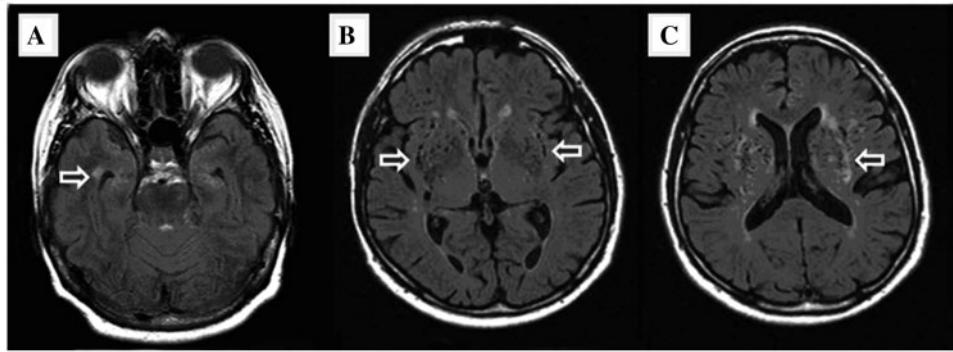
MRI findings suggestive of CADASIL in carriers of rare non-synonymous single nucleotide polymorphisms. Axial fluid-attenuated inversion recovery MRI images. (A) Subject 1350 with a V764A amino acid exchange showing a hyperintense rounded area of signal hyperintensity in the temporal lobe directly adjacent to the temporal horn of the lateral ventricle (*arrow*). Although signal changes at this location are not typically seen with age-related white matter changes, the abnormality can also not be considered specific for CADASIL, because CADASIL lesions usually extend to the most anterior parts of the temporo-polar white matter. (B) Subcortical lacunar lesions which have been reported with CADASIL (van den Boom *et al.*, 2002) are shown in the subsular region and operculum of the frontal lobe bilaterally. (C) demonstrates confluent hyperintensity of the external capsule (*arrow*), a finding that has high sensitivity, but low specificity in CADASIL (Markus *et al.*, 2002).
